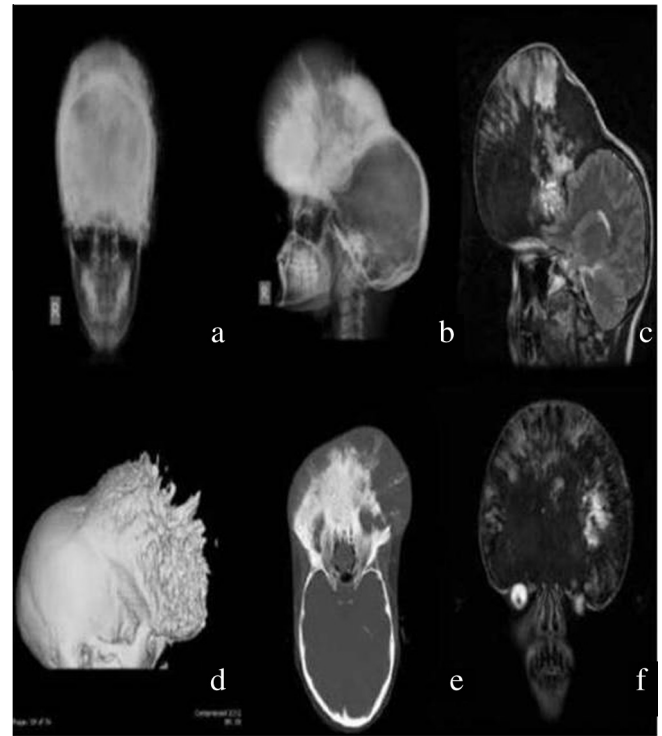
Plain (a) anteroposterior and (b) lateral radiographs showing the extent of the lesion and sclerotic spicules. T2-weighted (c) sagittal and (f) coronal MRI of the brain showing a heterogeneous lesion involving the bilateral superior orbital ridges. CT (d) three dimensional surface shaded reconstruction and (e) axial scans with bone windows showing spiculations arising from the outer table.
